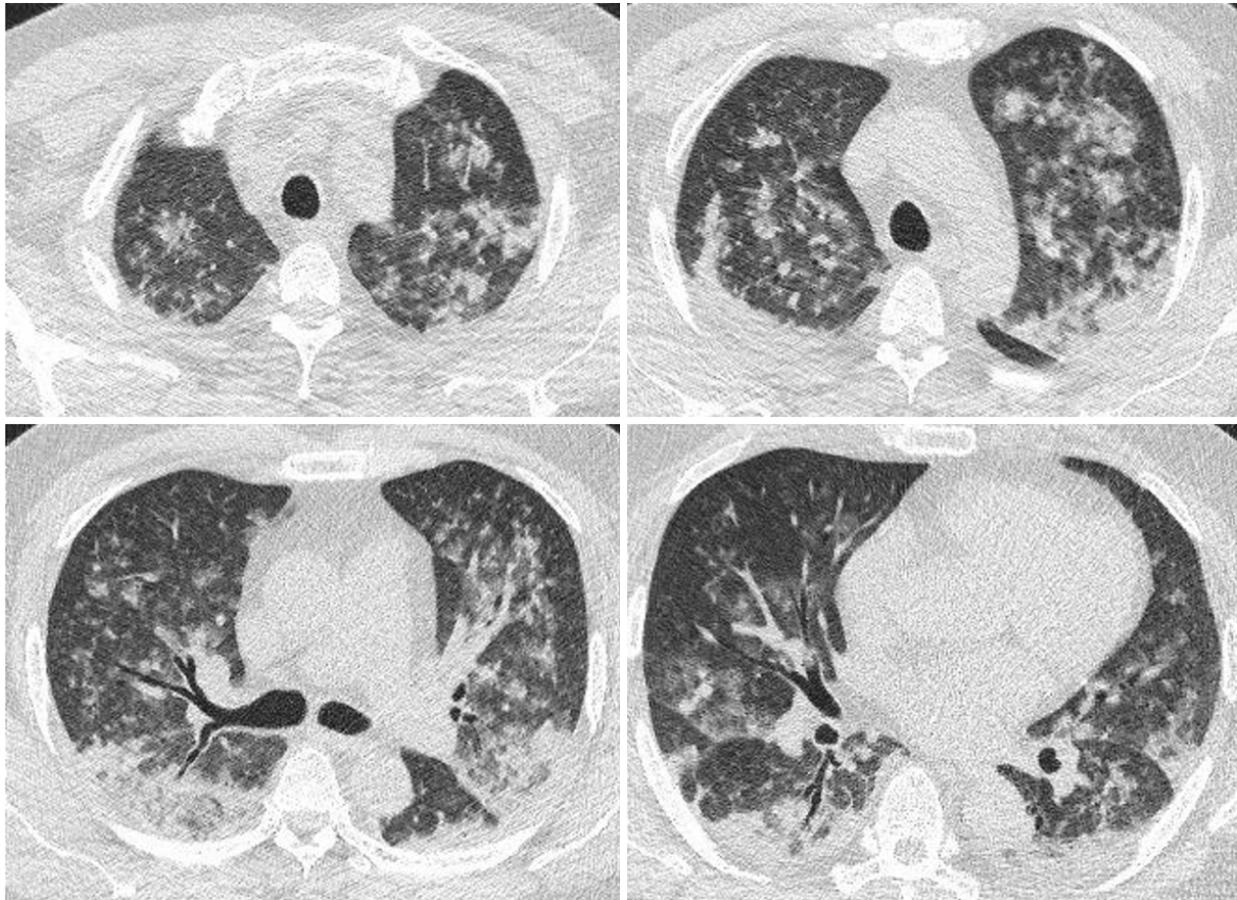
Chest computed tomography scan obtained on the day of emergency room visit presents bilateral peribronchovascular consolidation and ground glass opacity with sparing in the subpleural region.
